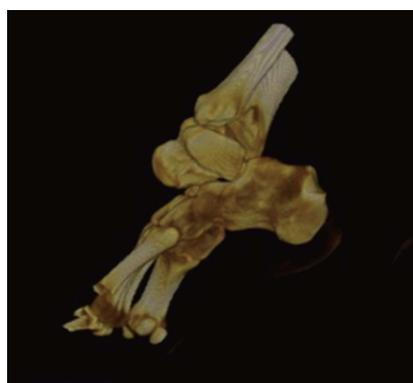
Computed tomography scan with 3D reconstruction image of the patient's ankle joint that demonstrates the dislocation of the talocalcaneus joint and the absence of a fracture.
